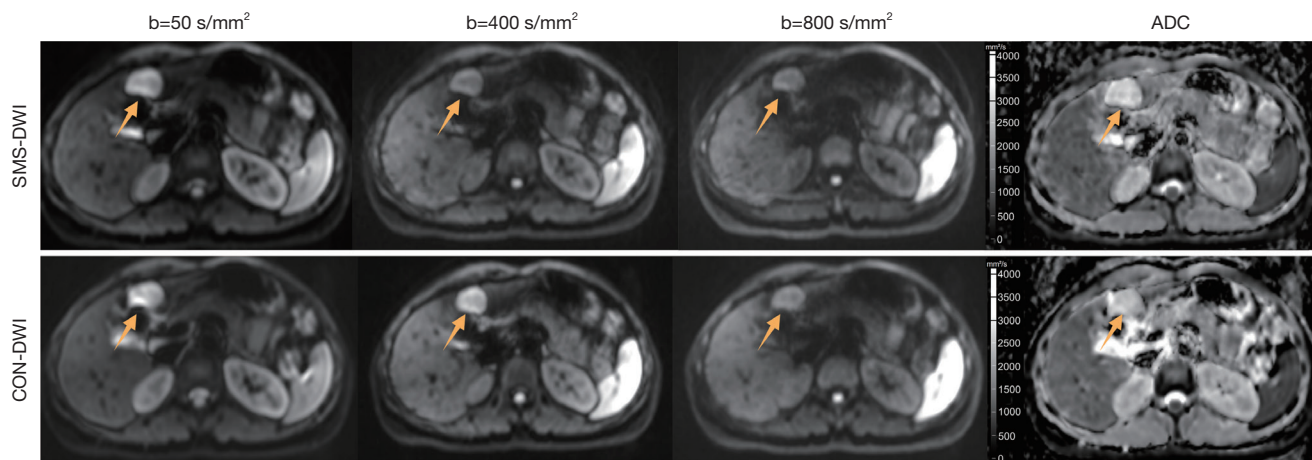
Representative images with SMS-DWI (upper row) and CON-DWI (lower row) of a 37-year-old female patient with hepatic cavernous hemangioma as confirmed through imaging and follow-up. Diffusion-weighted trace images with three different b-values ($b=50$, $b=400$, $b=800$ s/mm²) and the corresponding ADC maps are shown, with the arrows pointing to the lesion. The average ADC measurements were 2.46×10^{-3} mm²/s in SMS-DWI and 2.47×10^{-3} mm²/s in CON-DWI. SMS, simultaneous multislice; DWI, diffusion-weighted imaging; ADC, apparent diffusion coefficient; CON, conventional.
